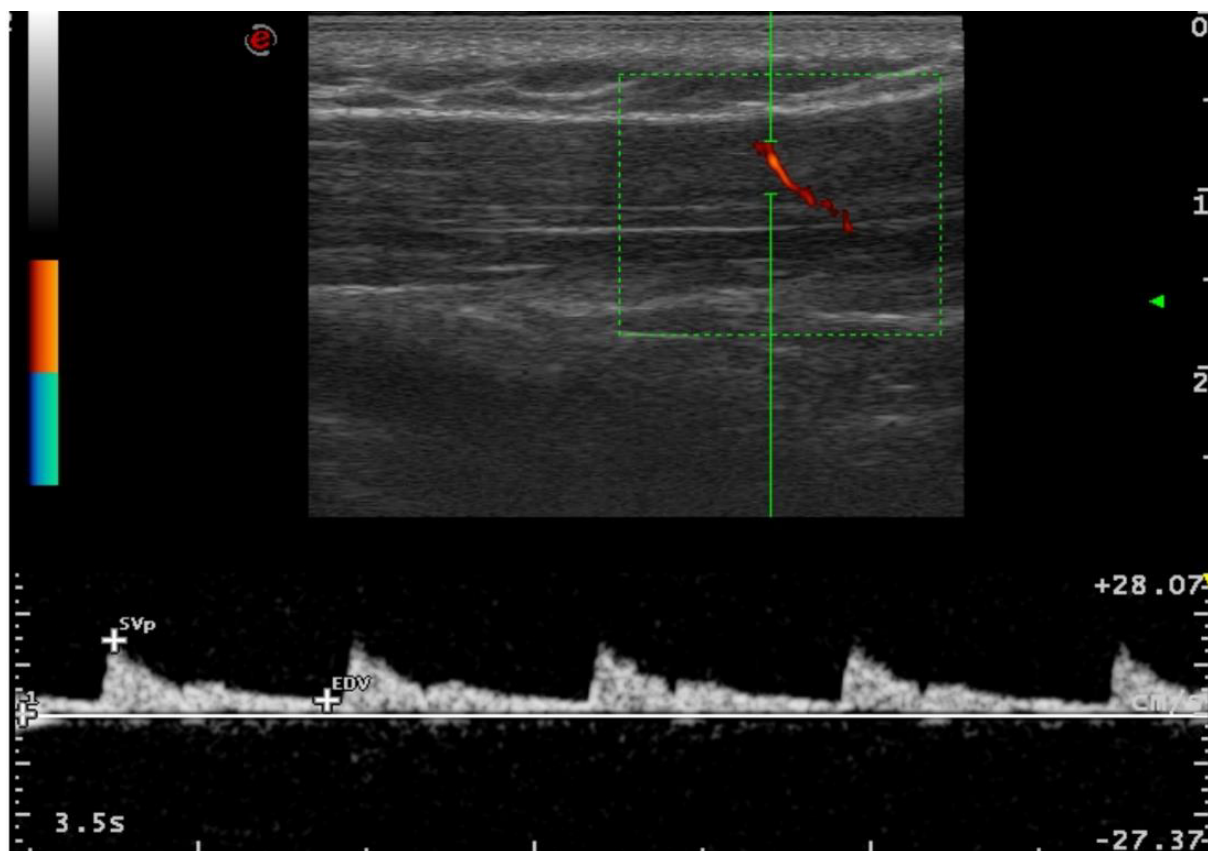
Sono doppler imaging of blood flow in the UT muscle
